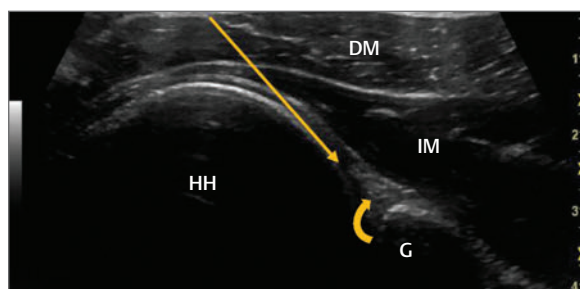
Ultrasound image of the posterior aspect of the humeral head (HH) and glenoid (G). The infraspinatus muscle (IM) may be seen deep to the posterior deltoid muscle (DM). The posterior labrum (curved arrow) may be seen as an echogenic triangle extending from the glenoid. The needle should be directed so that it lies against the posterior aspect of the humeral head deep to the labrum and posterior capsule (yellow arrow).
